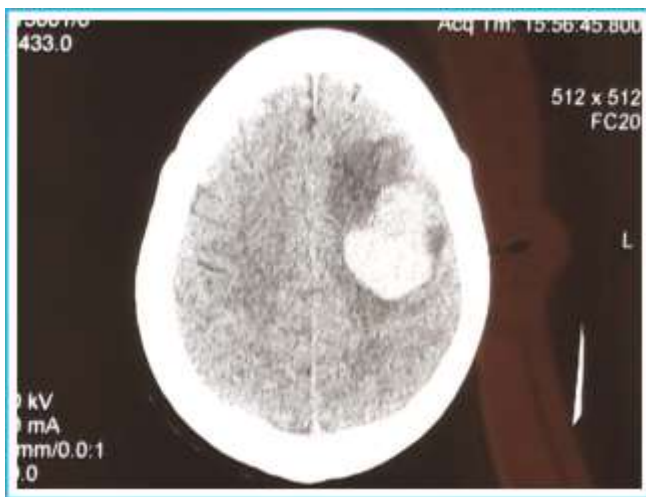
CT BRAIN showing hyperdense hematoma with surrounding edema.
